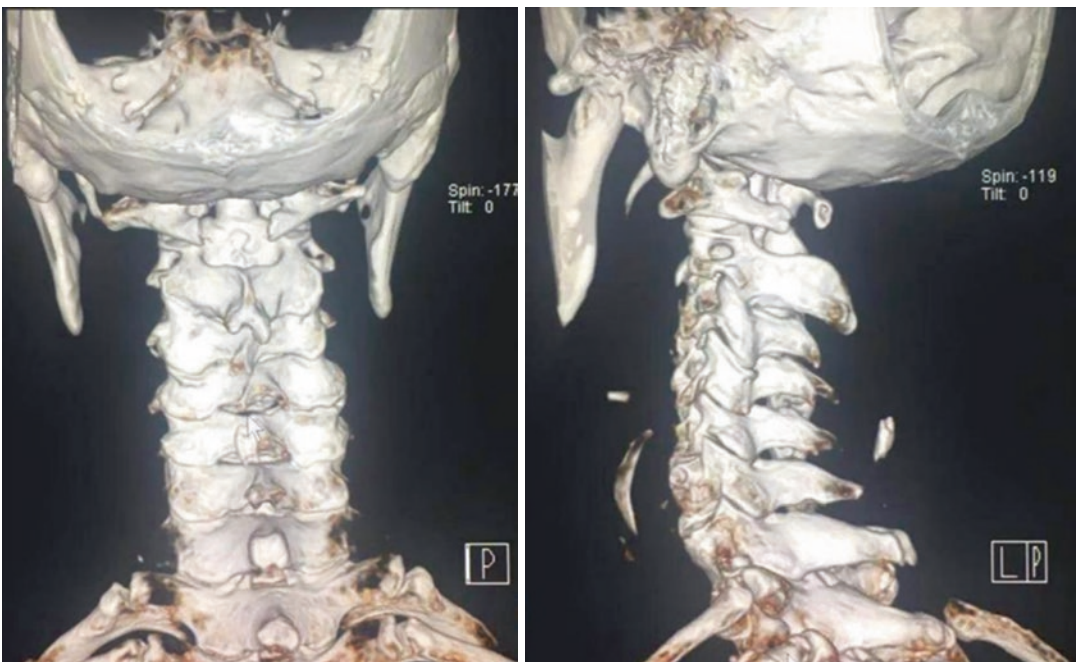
Postoperative CT Scan
